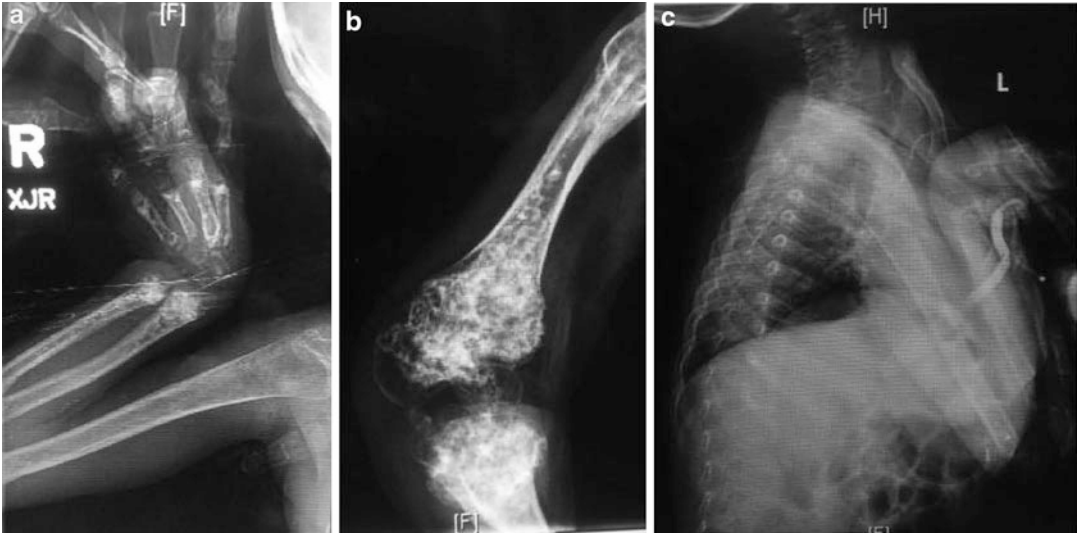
(a–c) The radiographs at 18 years of age showed widespread blastic lesions (bone marrow calcifications) involving the dia-metaphyseal portions of the distal radius and ulna as well as the metacarpals and phalanges. There were also subcutaneous calcifications in her forearms and elbows. The extremities appeared to be held in a flexion
